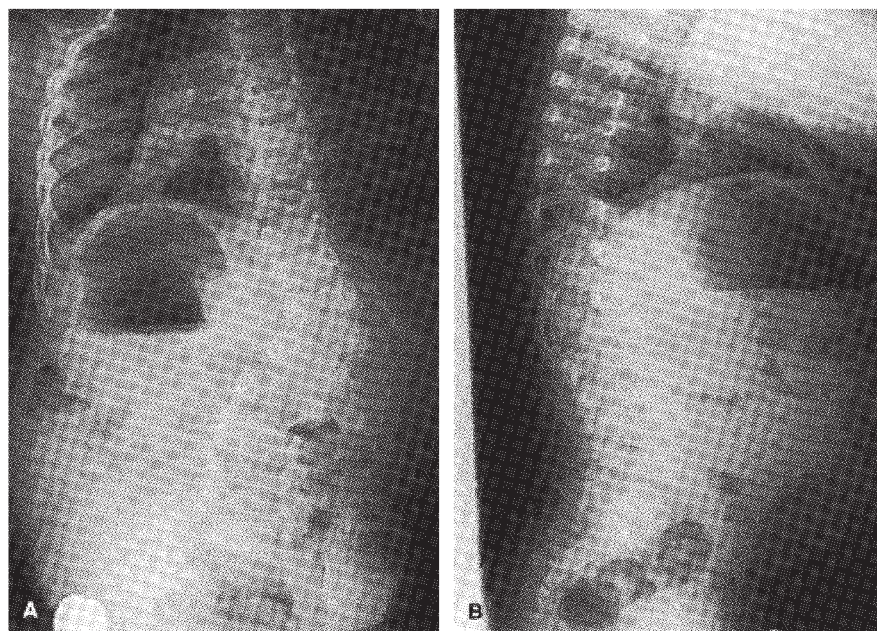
Preoperative posteroanterior and lateral radiographs showing an unbalanced 48° right thoracolumbar kyphoscoliosis resulting from an L2 fully segmented hemivertebra.
